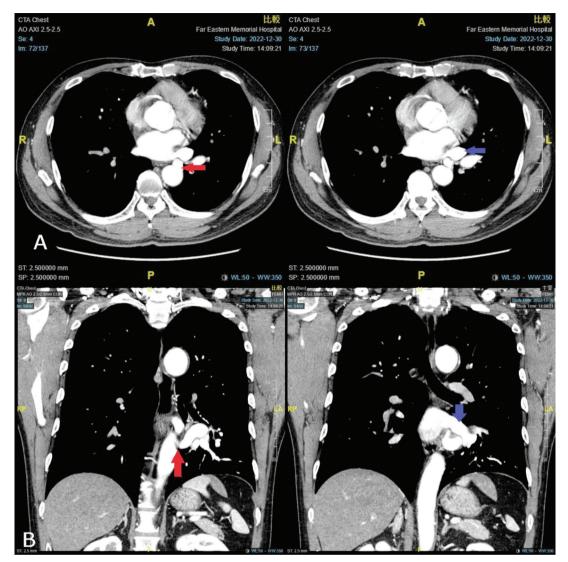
2A (sagittal) and 2B (coronal): Computed tomography angiography showed an abnormal artery (red arrow) rising from the thoracic descending aorta, that directly drained back to the left atrium, with a lack of connection to the pulmonary circulation.
